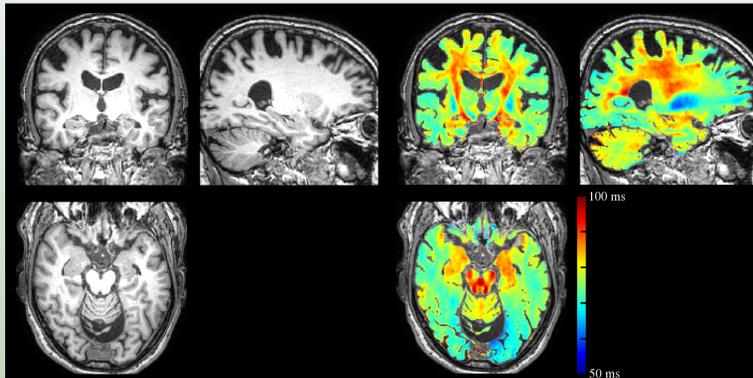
T1-weighted image and corresponding $T_{1\rho}$ map from a 72 year old male.
